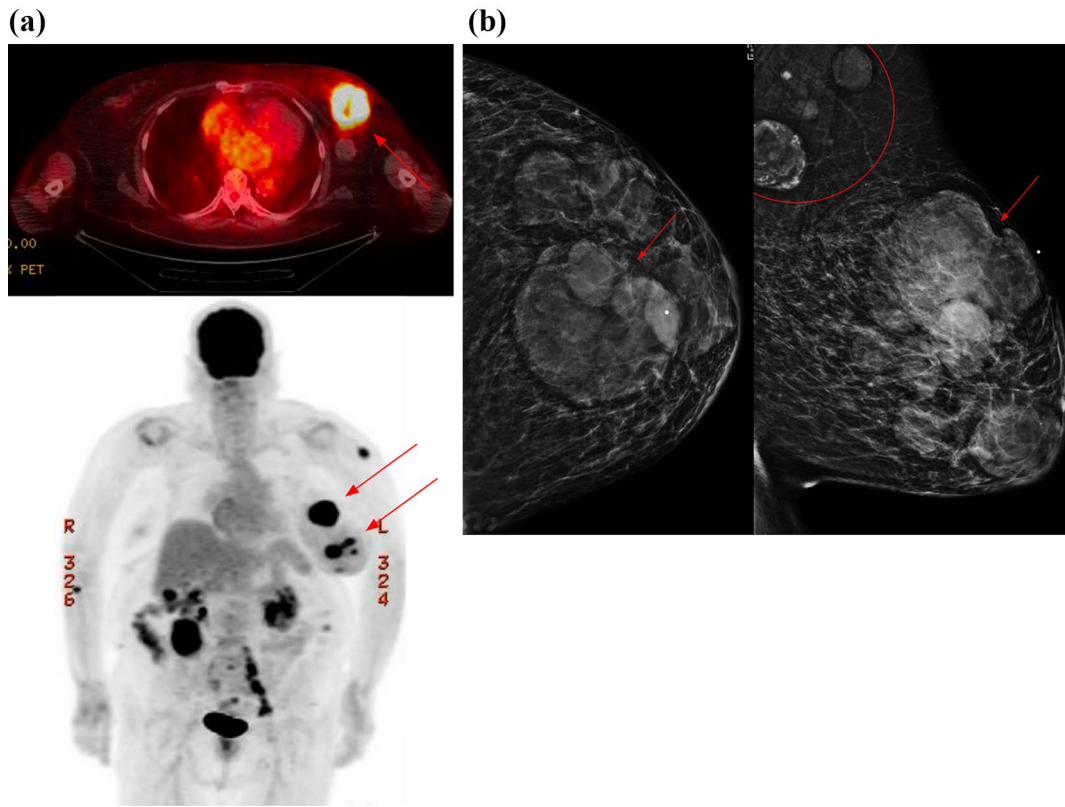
a PET–CT demonstrated multiple hypermetabolic left breast masses (arrows). b Diagnostic mammogram of the left breast in CC and MLO views showed multiple left breast masses, the largest breast mass at 12:00, 5 cm from the nipple (arrow), and corresponding to the patient's palpable abnormality denoted by a skin BB marker. Also noted were enlarged left axillary lymph nodes (circle). c Diagnostic ultrasound of the left breast demonstrated multiple irregular hypo-echoic masses with indistinct margins and heterogeneous echotexture in the left breast, spanning from 12:00 to 6:00. The largest of these masses measured approximately 7.0 cm at 12:00, 6 cm from the nipple, without significant internal vascularity. Additionally, there were left axillary lymph nodes with cortical thickening measuring up to 6 mm, with partially effaced fatty hilum
